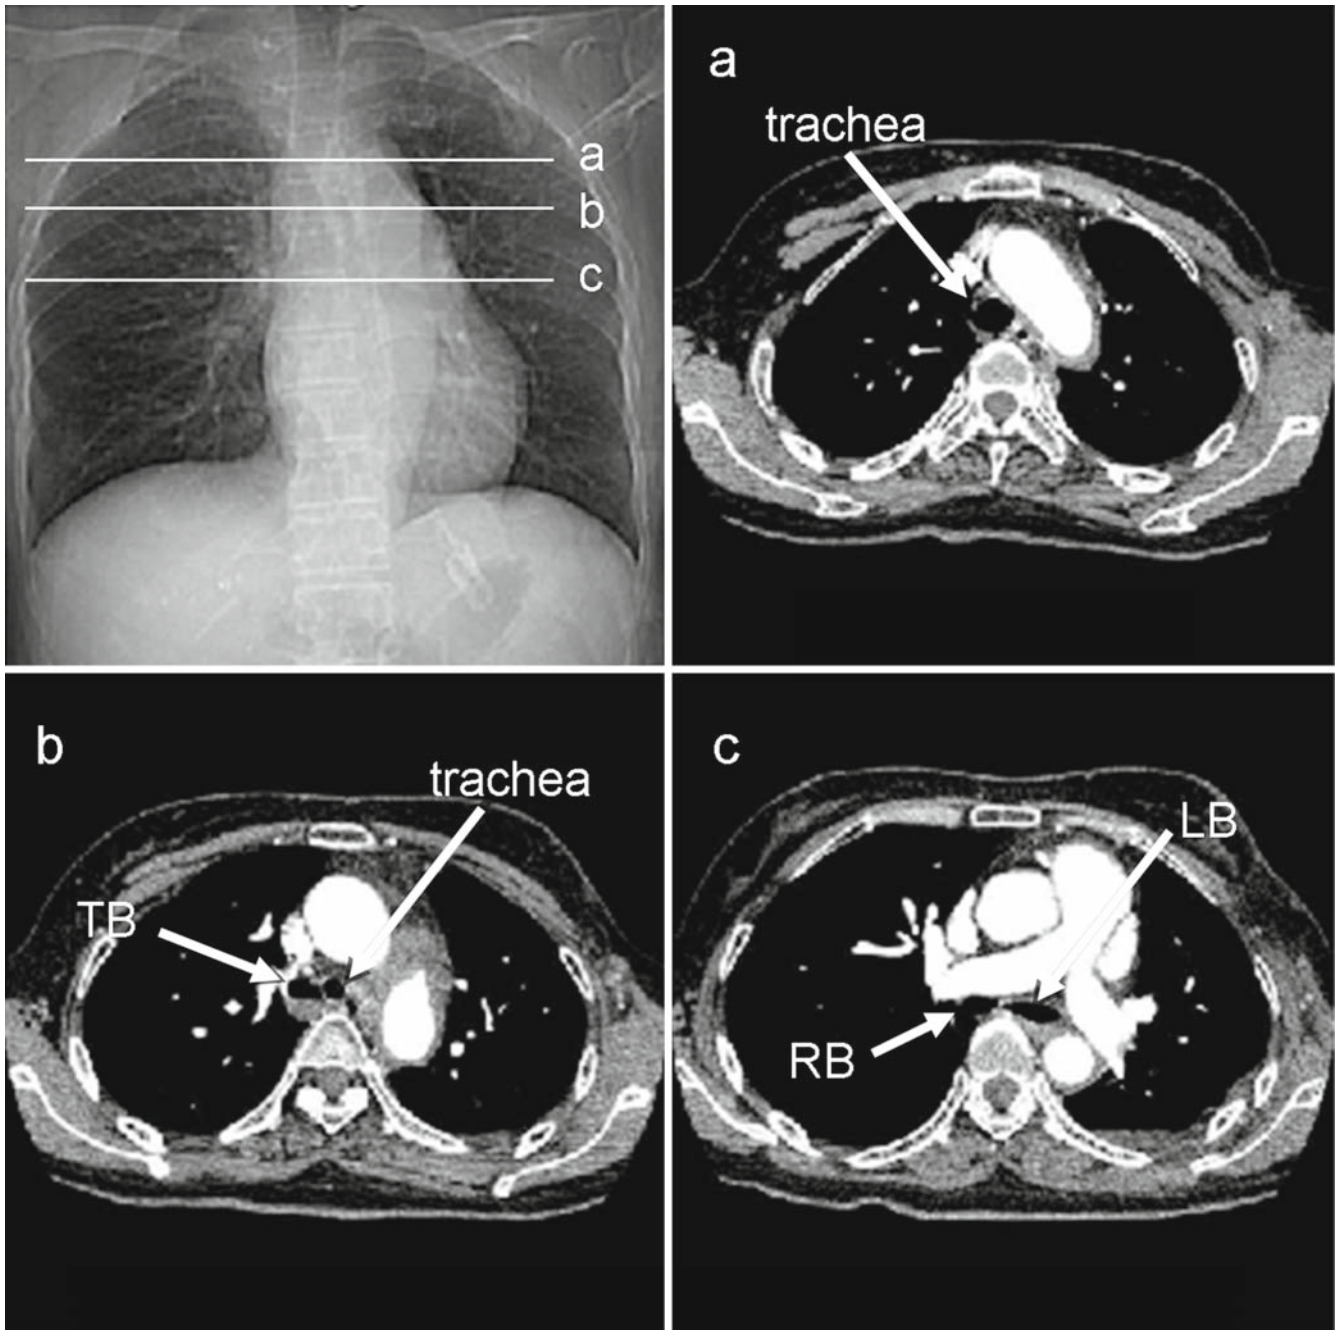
Preoperative plain chest computed tomography (CT) images at levels of the upper trachea (a), tracheal bronchus (b), and carina (c). *TB*, Tracheal bronchus; *LB*, left main bronchus; *RB*, right intermediate bronchus
